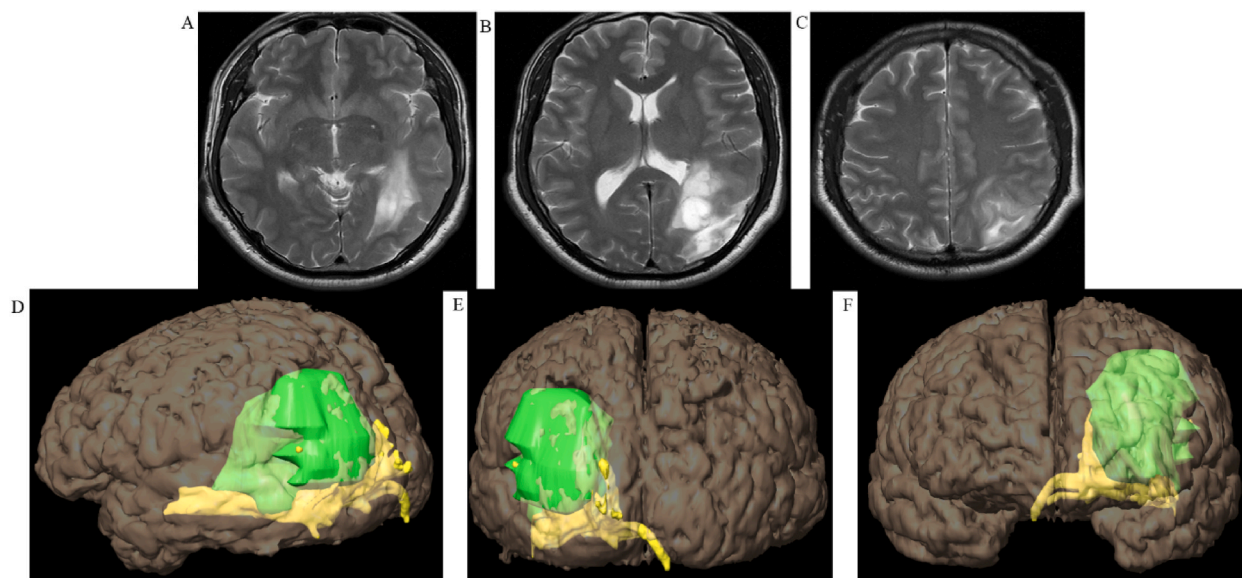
Visual Pathway Preservation in Occipital Lobe Tumor Resection: panels A–C present axial MRI views highlighting the tumor's position and extent, while panels D–F employ DTI imaging to elucidate the tumor's interaction with the visual tracts.
